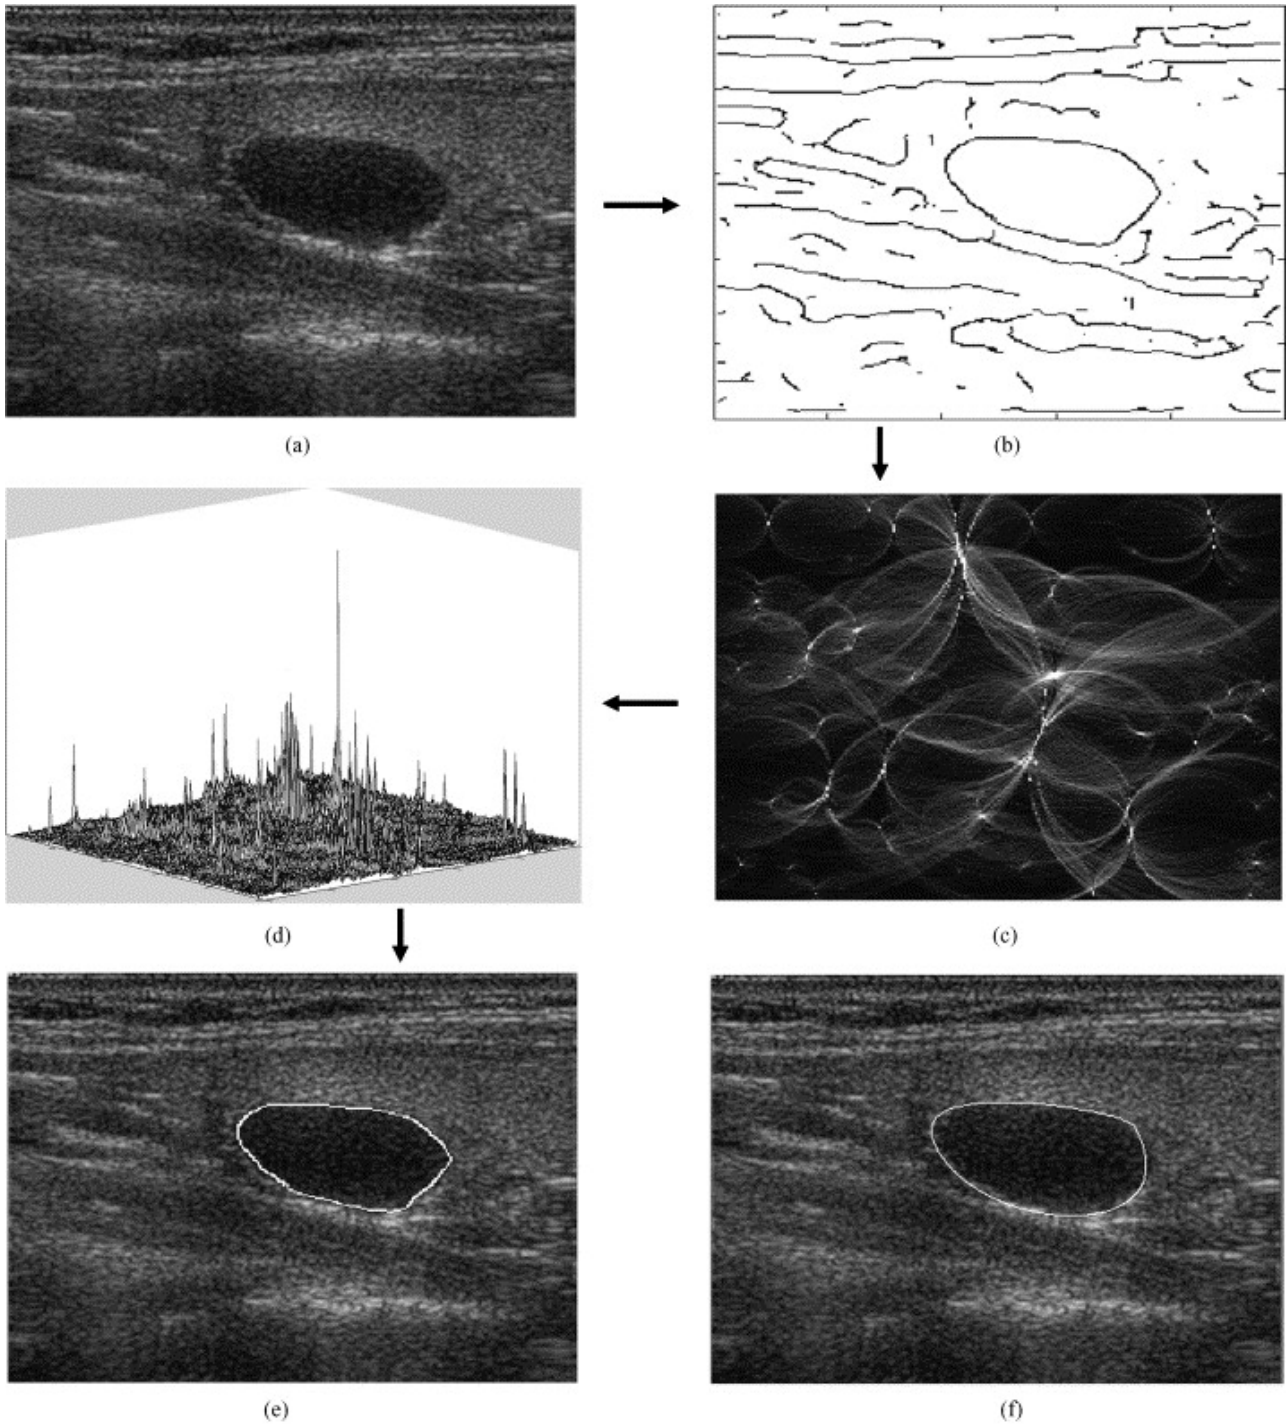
Example of Hough transform and automatic thyroid segmentation. (A) Ultrasound image with a hypoechoic thyroid nodule, (B) contour representation, (C) constrained Hough transform, (D) accumulator array, (E) hybrid model outcome, and (F) manually traced boundary. Figure taken with permission from [83].
